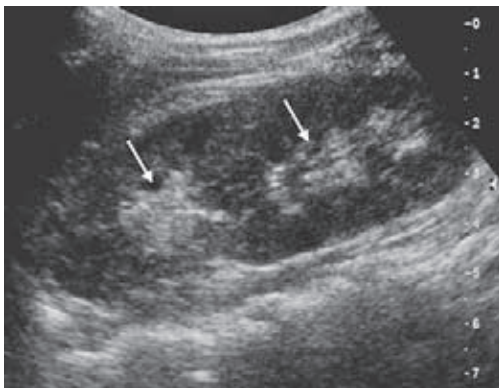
Uncomplicated ureteral duplication. Parasagittal ultrasound scan of left kidney shows two echogenic renal sinuses (arrows). The kidney is also enlarged. These findings are typical for an uncomplicated duplex kidney
